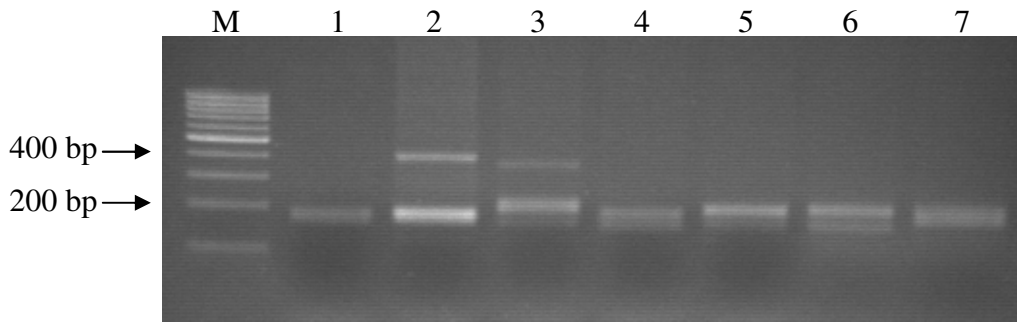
Amplification of both SCA8 and SCA12 loci by multiplex PCR (M: 100 bp ladder, 1: healthy control, 2: SCA8 (+) control, 23 and 94 (CTA/CTG) repeats; 3: SCA12 (+) control, 13 and 78 CAG repeats; 4-7: SCA samples)
